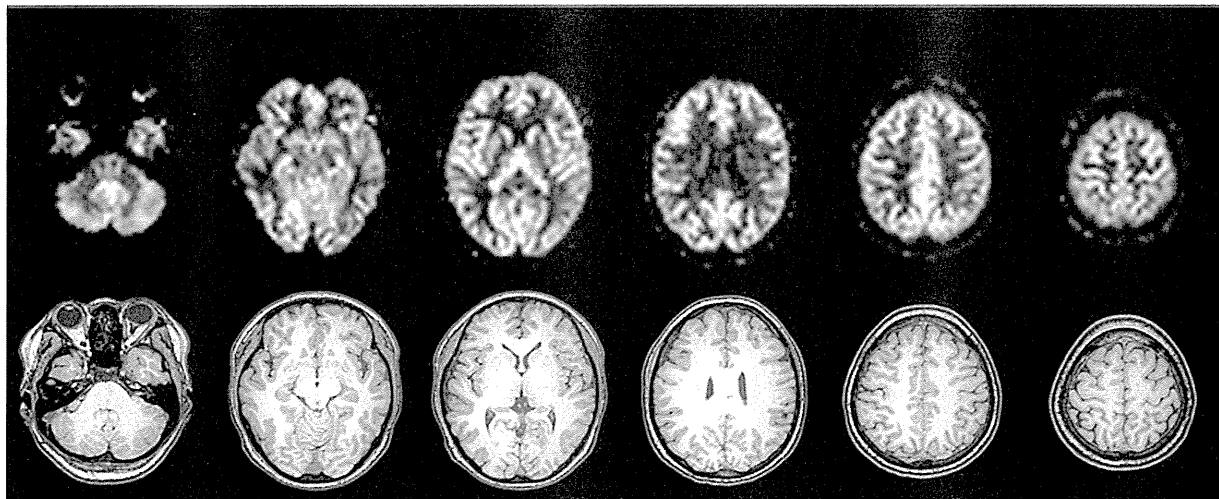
The upper row showed the typical example of ASL CBF maps acquired in a single healthy volunteer, and lower row showed corresponding slices of T1-weighted image.
